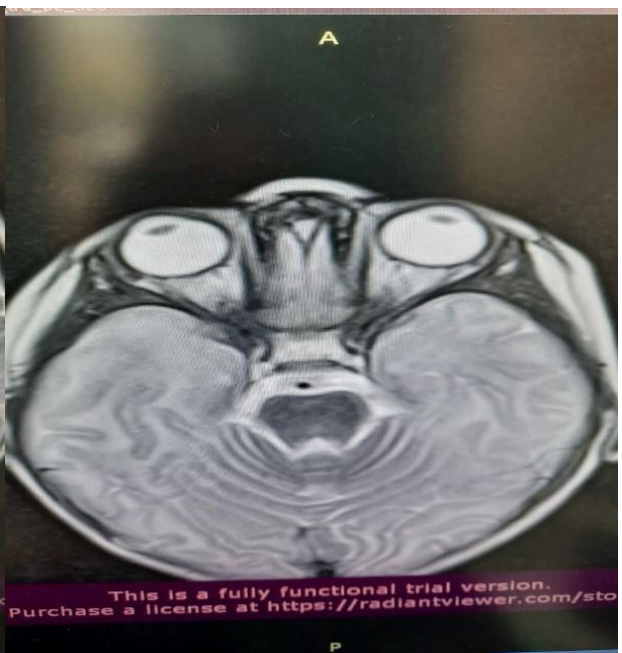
MRI brain of patient-with normal Findings.
